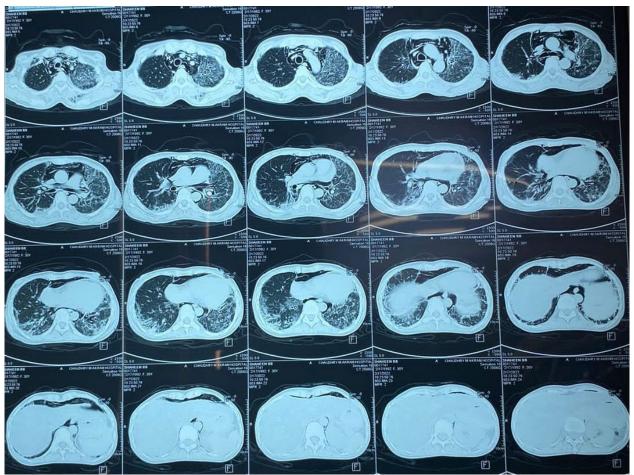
HRCT Chest on admission
